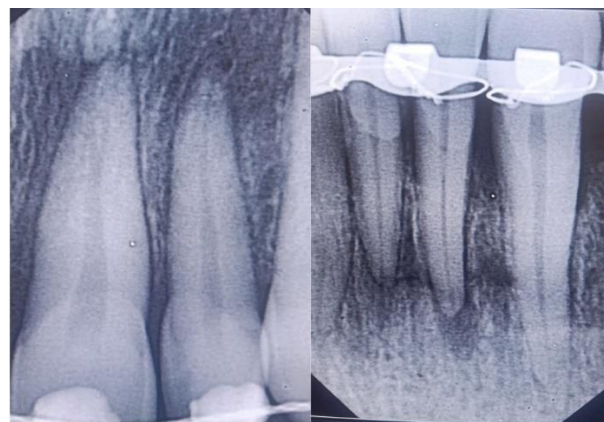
Control periapical radiograph after maxillary splinting and mandibular rigid fixation
